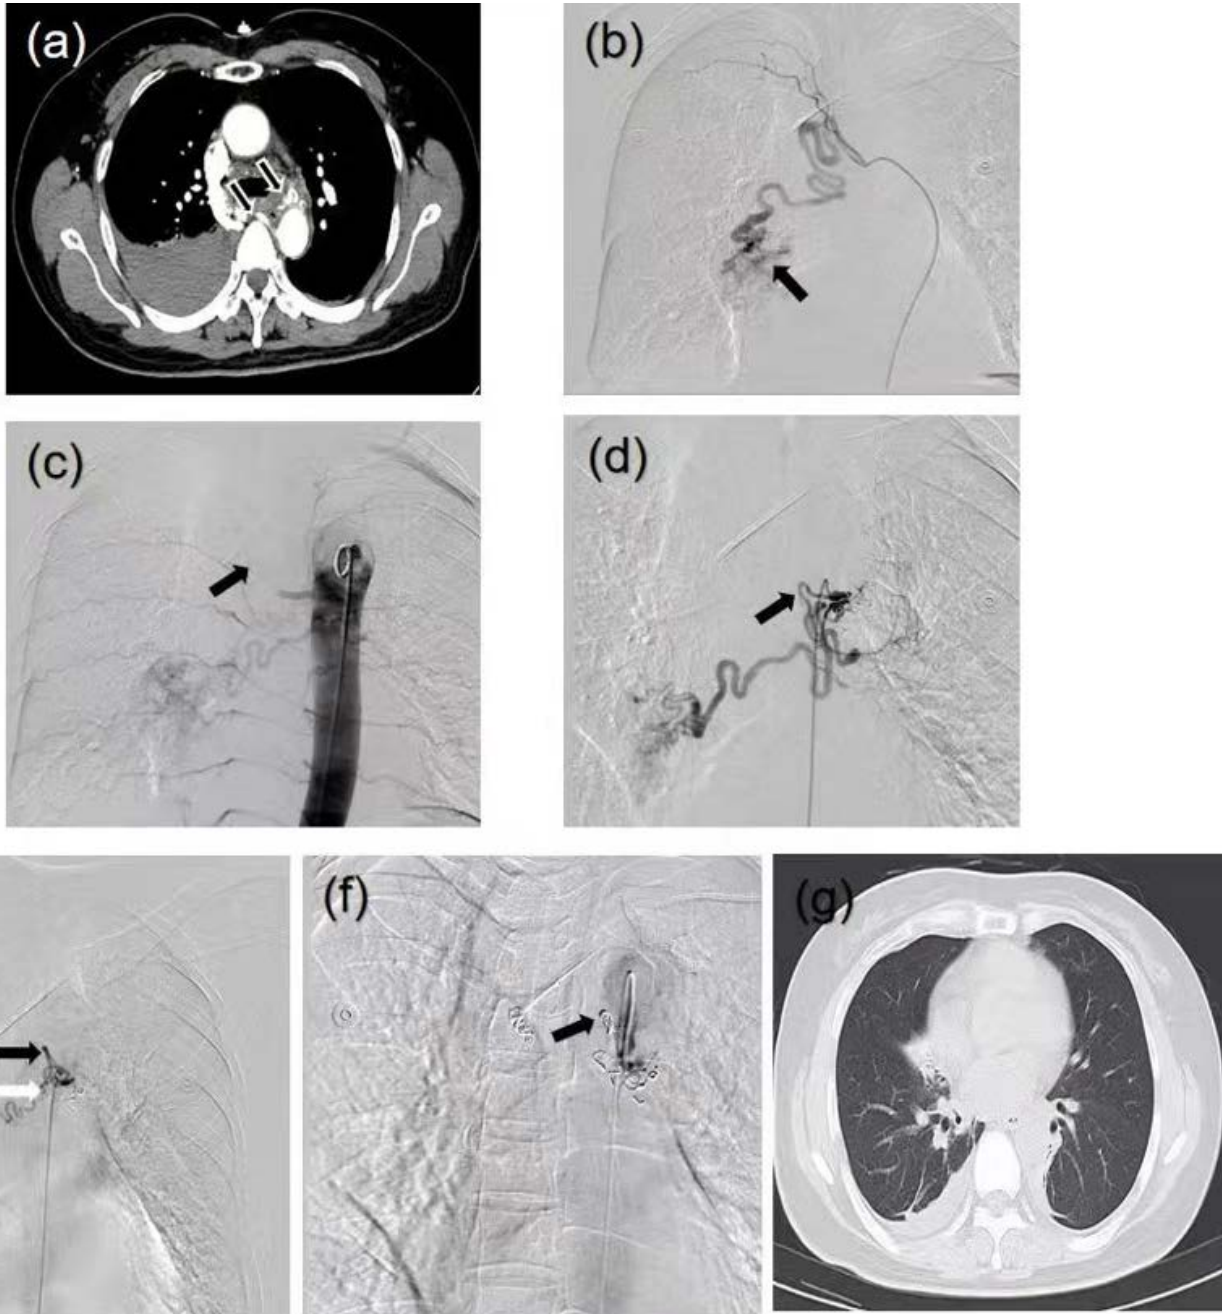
BAE treatment for RHBA. (A) Initial contrast-enhanced thoracic CT: Hyperdense right pleural effusion (41-58 HU) in posterior mediastinum and right hemithorax. Tortuous, dilated, and disorganized vascular structures in posterior mediastinum and right hilum. (B) DSA: Long-segment aneurysmal dilatation of right bronchial artery. Terminal contrast extravasation with disorganized vascular bed. (C) Post-embolization thoracic aortography (subtraction technique): Proximal coil embolization of superior RHBA. Two persistent hypertrophied bronchial arteries supplying hemorrhage territory. (D) Embolization of inferior RHBA: Proximal coil deployment with gelatin sponge augmentation. Visible communicating branch (arrowhead). (E) Post-communicating branch embolization: Coil occlusion of communicating branch (white arrow). Abnormal vascular blush in middle RHBA (black arrow). (F) Final embolization outcome: Proximal coil deployment in middle RHBA. "Stump-like" occlusion of all three RHBA. Complete resolution of abnormal vascular blush. (G) 12-day follow-up non-contrast CT: Interval resolution of bilateral pulmonary opacities. Significant reduction in right pleural effusion. Improved re-expansion of right lower lobe.
